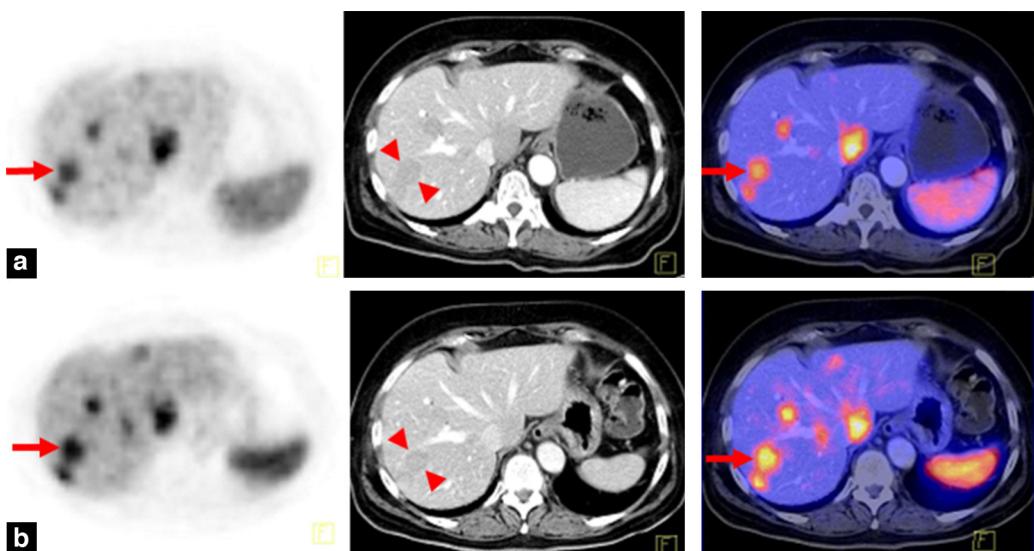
Equivocal findings after PRRT. A 60-year-old woman with metastasized neuroendocrine tumor of the ileum (PET, CT, and Fusion). Before (a) and after (b) PRRT with 3815 MBq ^{90}Y -DOTATOC. Post-therapeutic equivocal findings with increase of ^{68}Ga -DOTATOC uptake (arrows), but morphologically stable disease (arrowheads), falling tumor markers and good general condition. Follow-up showed tumor progression (CT, tumor markers, clinical condition) after 9 months. Pre-therapeutic ^{68}Ga -DOTATOC uptake was 17.9; pre-therapeutic assumed ^{90}Y -DOTATOC uptake was 1.0 MBq/g.
